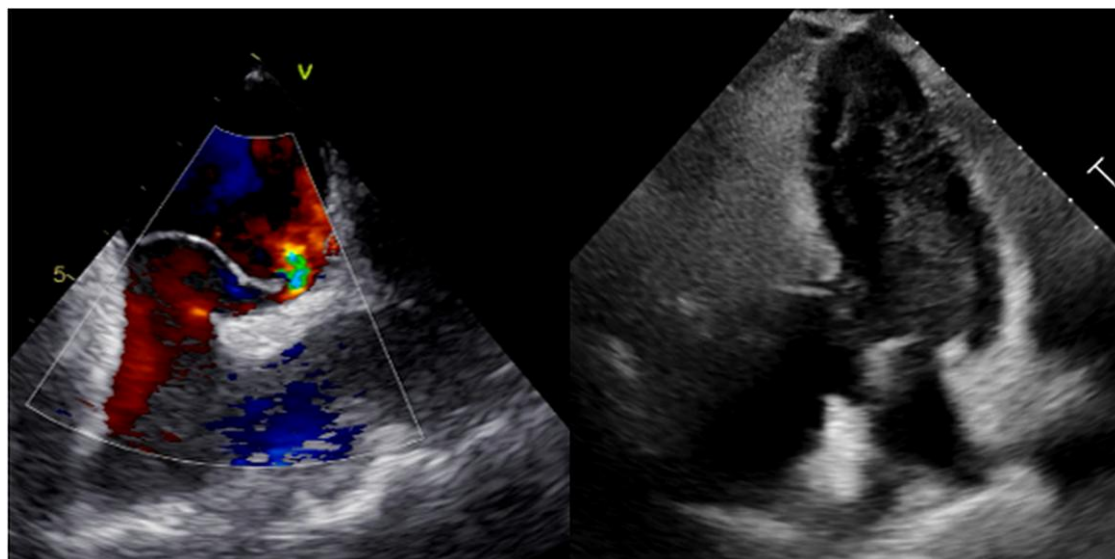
Transthoracic echocardiography of the PFO with Doppler and agitated saline contrast (bubble study).
